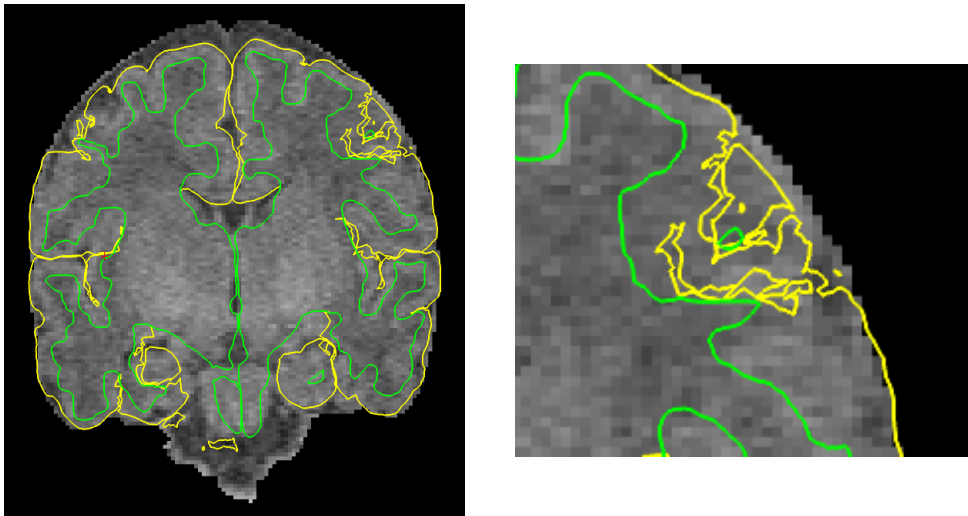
(a) Intersection of tessellated WM (green line) and GM (yellow line) surfaces with the MRI volume for newborn data. In some regions, both surfaces collapse to a single point preventing a correct pial surface extraction. (b) Zoom to a central region of the brain. Due to technical limitations, the convolving pattern of the CSF-GM interface is lost.
